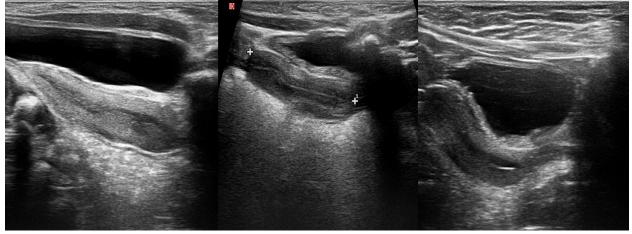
Ultrasonographic views of the uterus in infants with Congenital Adrenal Hyperplasia: fundus completely larger than cervix, fundocervical ratio < 2 (B), and fundus size equal to the cervix (C)
